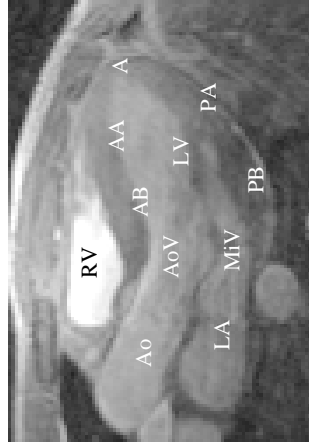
MR image with the five regions of the ventricular wall indicated: AB: basal half of anterior wall, AA: apical half of anterior wall, A: apex, PA: apical half of posterior wall, PB: basal half of posterior wall. Furthermore, the position of the left ventricle (LV), the left atrium (LA), the right ventricle (RV), the mitral valve (MIV), the aortic valve AoV and the aorta (Ao) are indicated.
